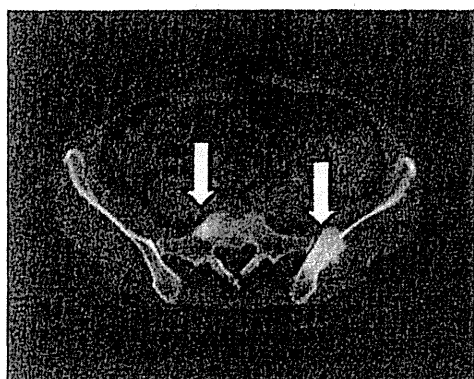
Bone metastases were revealed using computed tomography (arrow).
